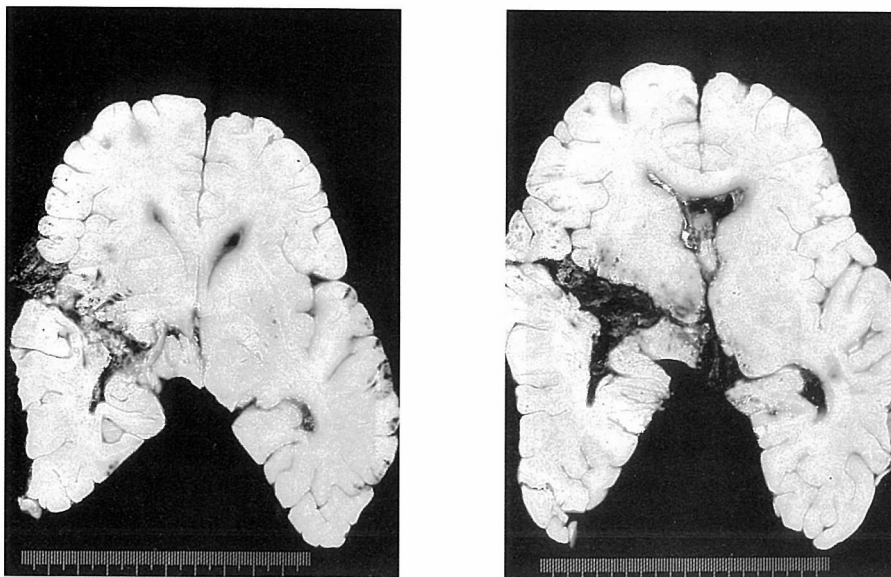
A gunshot tract and hemorrhage shown in the horizontal section were the same as in the CT-scan. Many petechiae were present at the top of the gyri in the temporal and parietal areas.
